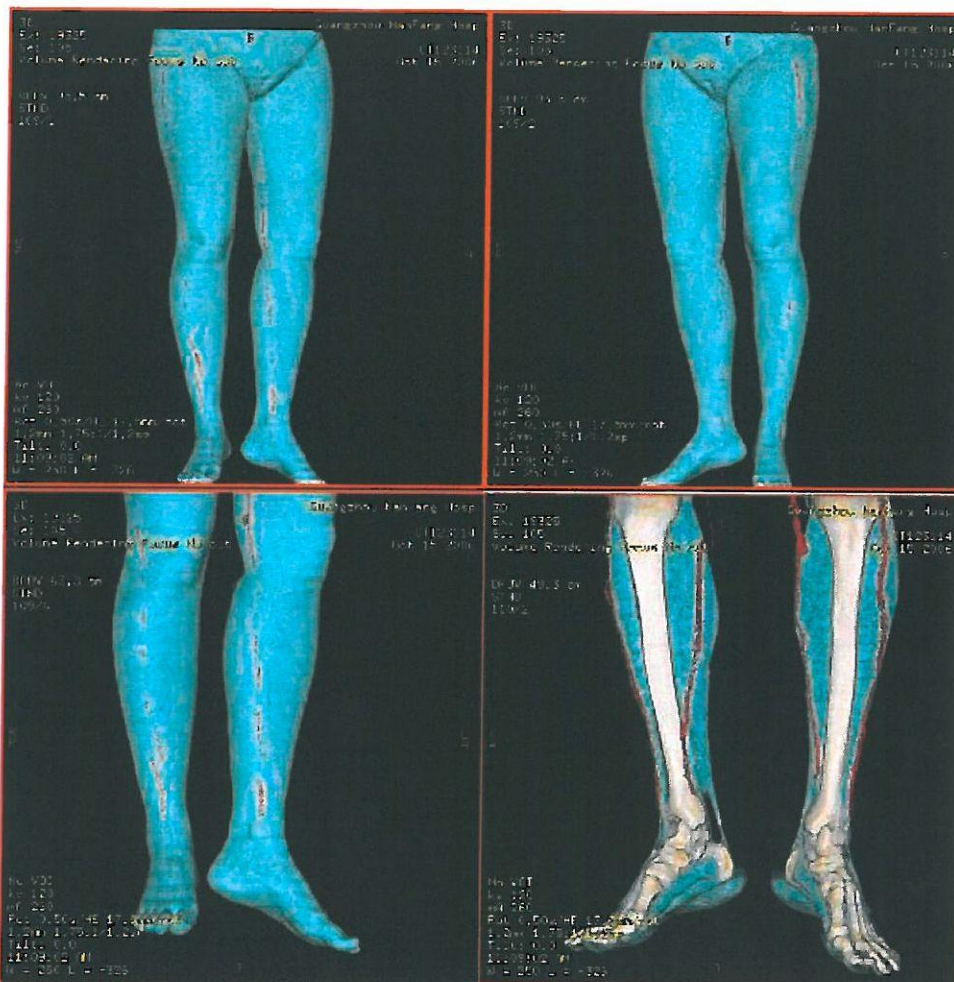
Reconstruction of the 3-D structures of the areas containing rich connective tissues based on the CT images of the lower limbs.
